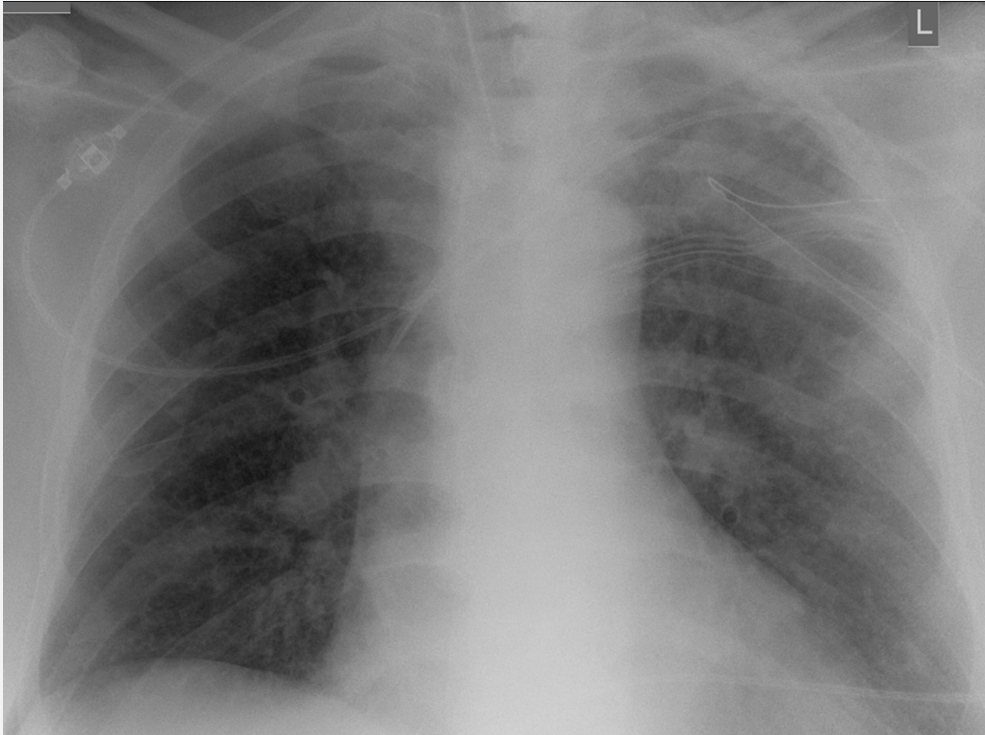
Conventional chest X-ray demonstrates a bipulmonary reduction in transparency, most likely from known atypical infiltrates from COVID-19. No evidence of pneumothorax is detected in this imaging plane.
